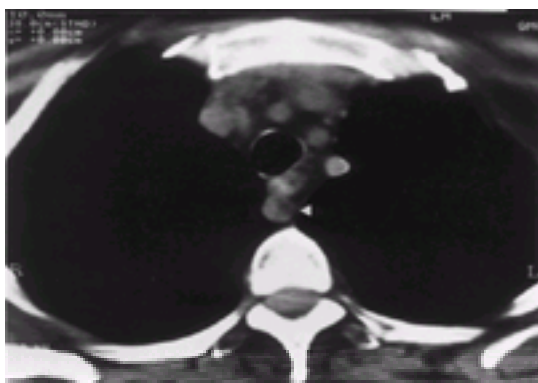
CT scan through the chest at the level of the great vessels. The aberrant right subclavian artery arises from the distal part of the aortic arch as its last branch lying posterior to the oesophagus (arrowhead).
